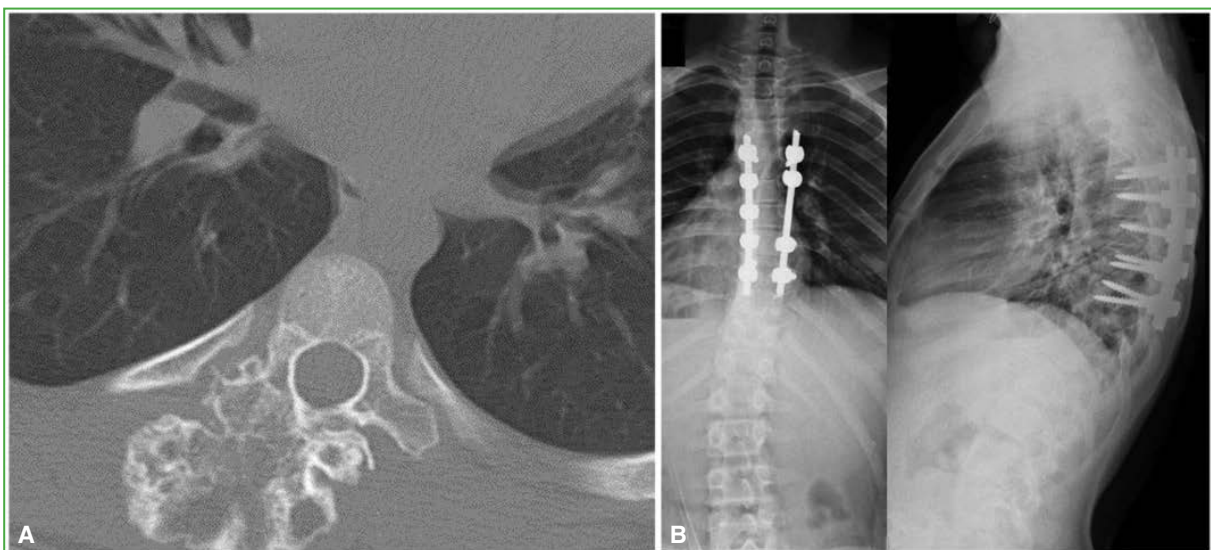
Case 9. A. Computed tomography of the thoracic spine, axial plane, showing a large extracanal osteochondroma (103 cm^3) at T6. B. Anteroposterior and lateral radiographs of the thoracic spine at 1 year and 5 months postoperatively, following intralesional resection and arthrodesis with pedicle instrumentation. Note the absence of tumor recurrence.
